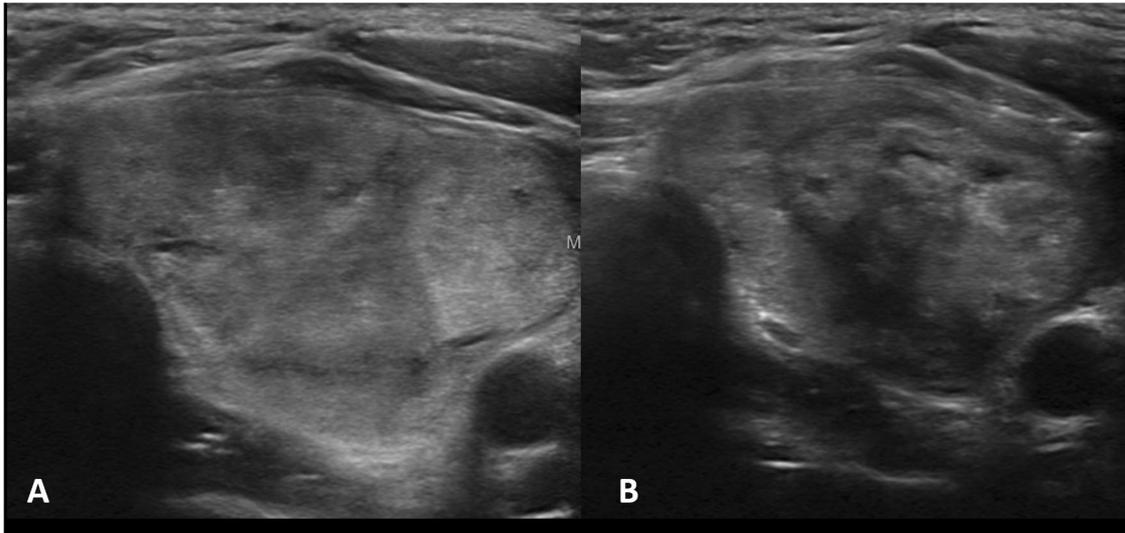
A left lobe thyroid nodule treated by high-intensity focused ultrasound (HIFU). a Ultrasound before treatment (nodule's volume 10.5 mL). b Ultrasound after 6 months with nodule size reduction
